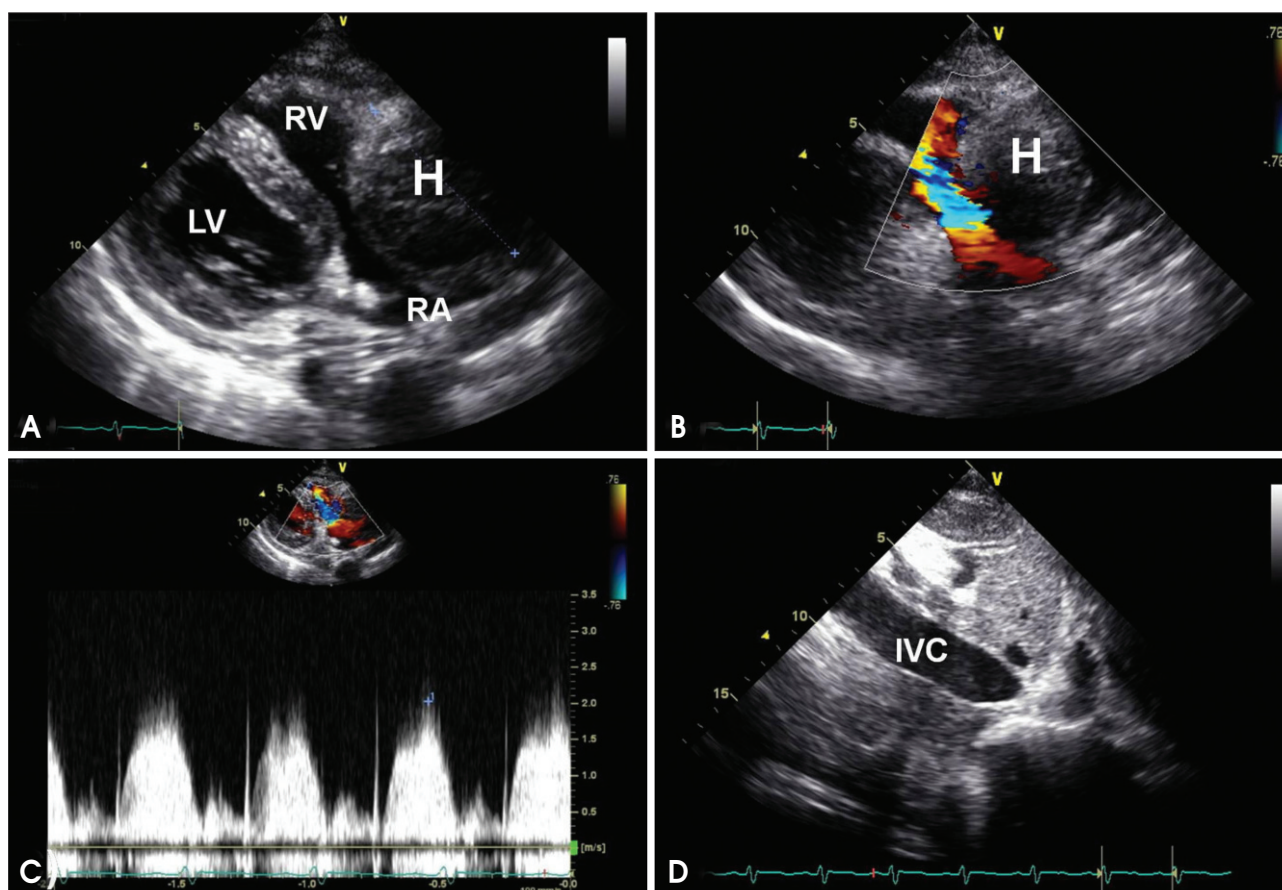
Transthoracic echocardiography on admission. A: Two-dimensional image showed a 59×55 mm-sized mass (H) adjacent to the right heart extrinsically compressing the tricuspid annulus and small amount of pericardial effusion. B and C: Color Doppler study showed accelerated color flow from the RA to the RV with peak pressure gradient of 16 mmHg. D: IVC was dilated to 27 mm and not collapsed during inspiration. H: hematoma, LV: left ventricle, RV: right ventricle, RA: right atrium, IVC: inferior vena cava.
